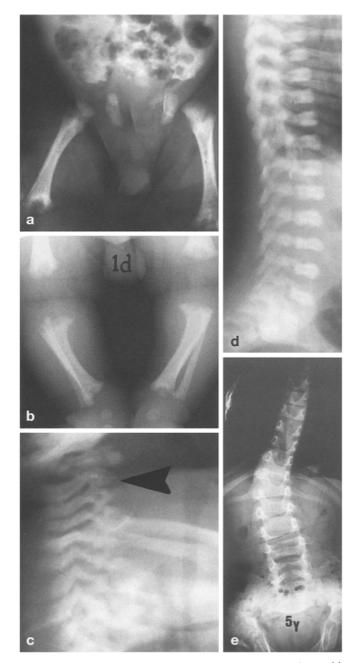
Case 1, plain radiographs. a-d One day old. a,b Transradiant defects, characteristic of enchondromatosis. Shortened sacro-iliac notches with flattened, triradiate acetabular roofs. Irregular outlines of the iliac crests. Shortness of the right femur and tibia. The knee ossification centres are absent. c Delayed ossification of the cervical spine (arrow). d Platyspondyly of the lumber spine. e Five years old. Short segment scoliosis without obvious malsegmentation. Wide lumbar spinal canal
